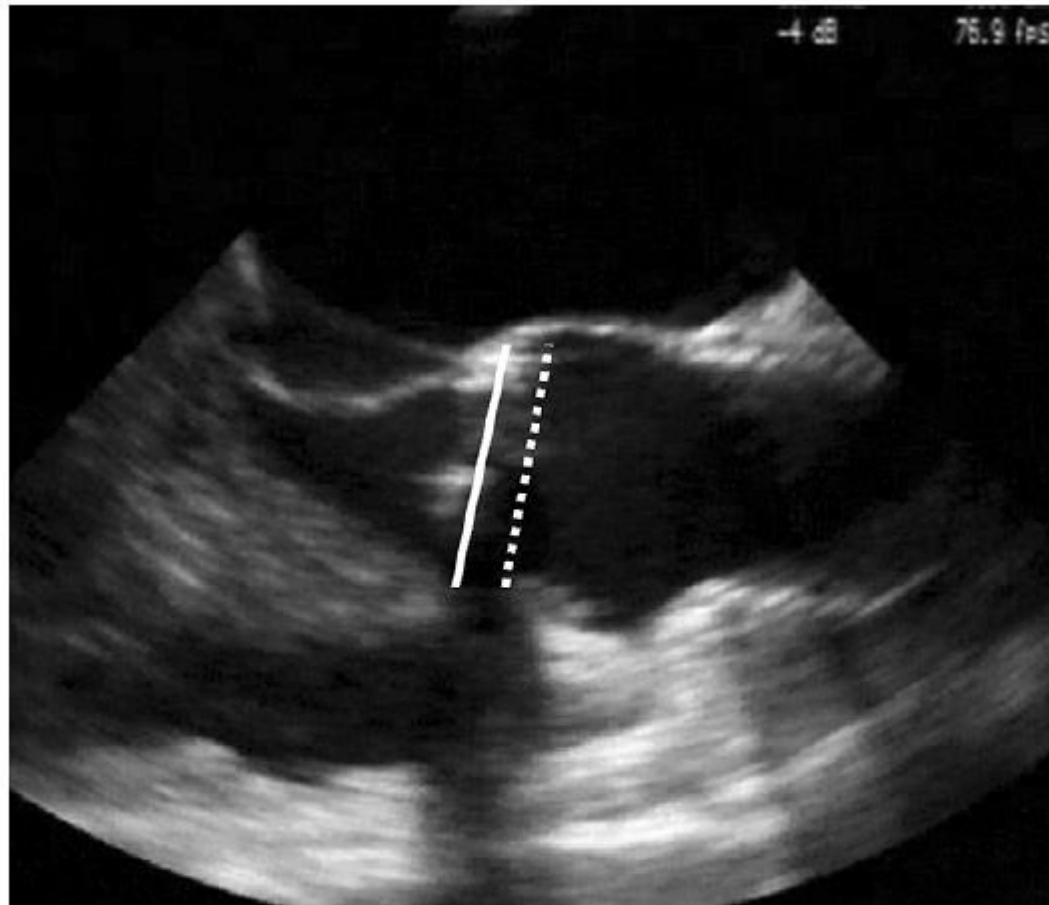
Typical echocardiogram of a patient with symmetric prolapse after separate valve repair and aortic replacement. The dotted line marks the coaptation level of the free margins, the solid line, the level of the aortic insertion. The most striking finding is an abnormally low height difference of 4 mm between central cusps and aortic insertion.
